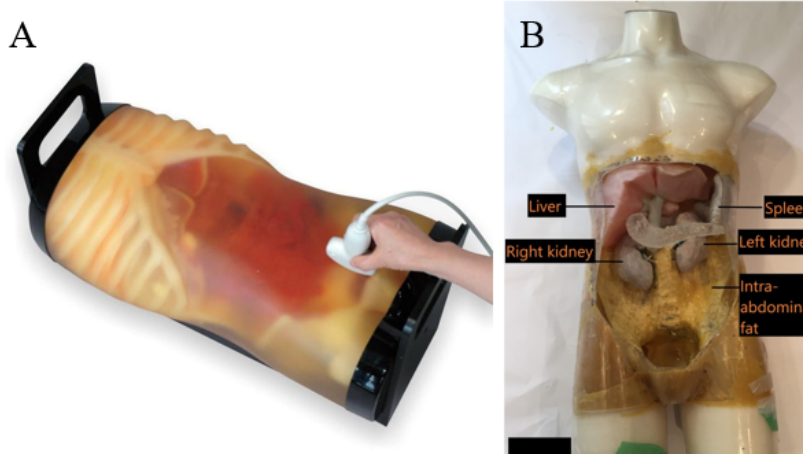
(A) Commercial ultrasound manikin for abdominal pathology training lacks modularity, making large cohort training costly (figure reproduced from [66]). (B) Anwari et al. X-ray manikin with modular organ inserts was made from a variety of materials, which demonstrated radiological accuracy but used gel-filled 3D-printed shells unsuitable for efficiently obtaining anatomical fidelity and US compliance (figure reproduced from [4]).
